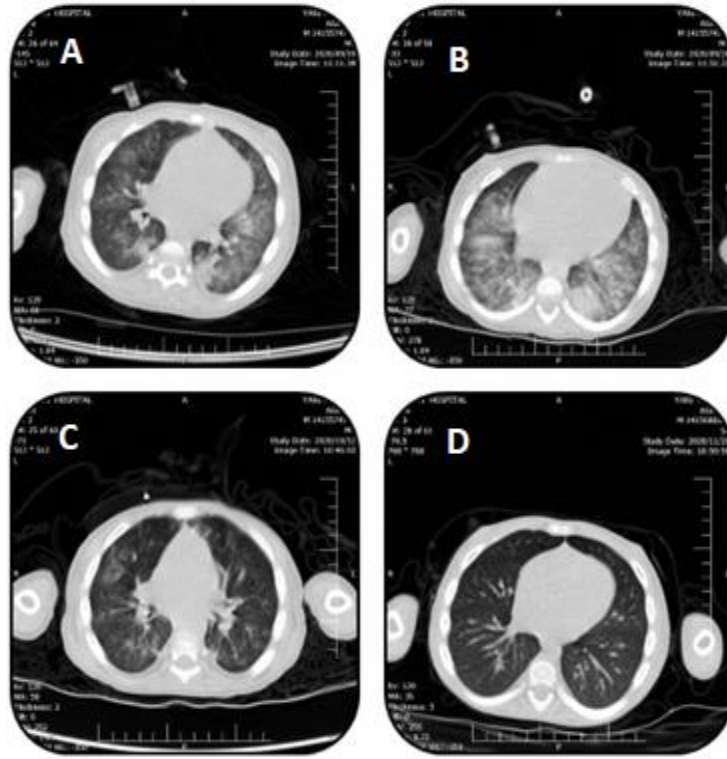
Chest CT from the HSCT patient at different intervals. A) Patchy ground-glass opacities in both lungs on day +16 post-HSCT; B) bilateral multifocal dominantly patchy ground-glass opacities and consolidations on day +24 post-HSCT; C) reduced parenchymal opacities compared to the previous CT on day +40 post-HSCT; D) complete resolution of opacities on day +90 post-HSCT.
